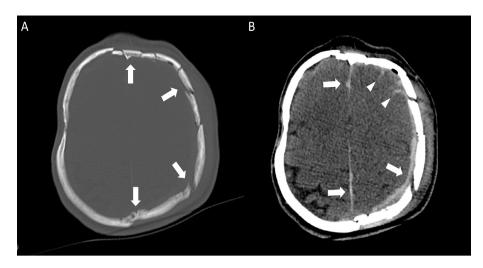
Head CT scan of the patient. A) The bone window shows partially displaced fractures in the left hemisphere of the cranial vault, involving both the frontal and occipital poles (arrows). B) The soft tissue window shows subdural hematoma along the left hemisphere and the cerebral falx (arrows) and subarachnoid hemorrhage in the left frontal sulci (arrowheads).
